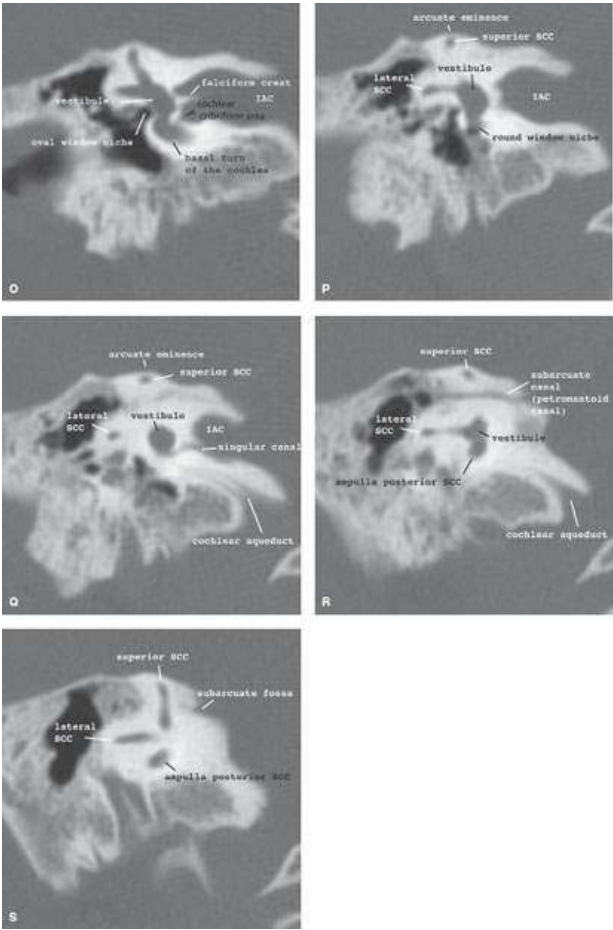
Normal axial (A–L) and coronal (M–S) computed tomography anatomy of the internal auditory canal, vestibular aqueduct, cochlear aqueduct, subarcuate canal, and singular canal.
